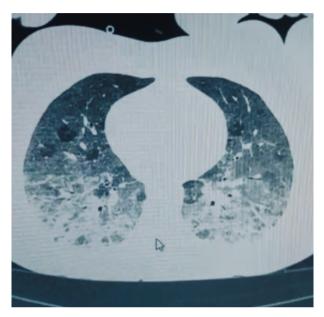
Chest CT scan showing areas of diffuse ground-glass pattern, with small bilateral areas of opacity
